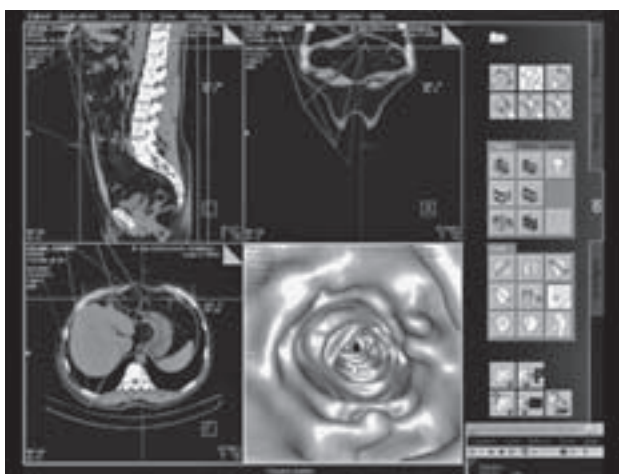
Fly-through within the transversal colon was shown. Virtual endocamera was located approximately in the mediosagittal plane and its view oriented towards the right side of the body. A small amount of residual fecal mass and contrast medium was presented. For an inexperienced user, it is important to say that these residuals may be mistaken for small intestinal polyps therefore it is important not only to look at 3D reconstruction but also reference CT reconstructions in all the three coordinate planes. The relationship of this endoluminal intersection and position of virtual endocamera to surrounding abdominal anatomical structures may also be studied on these three planes.
